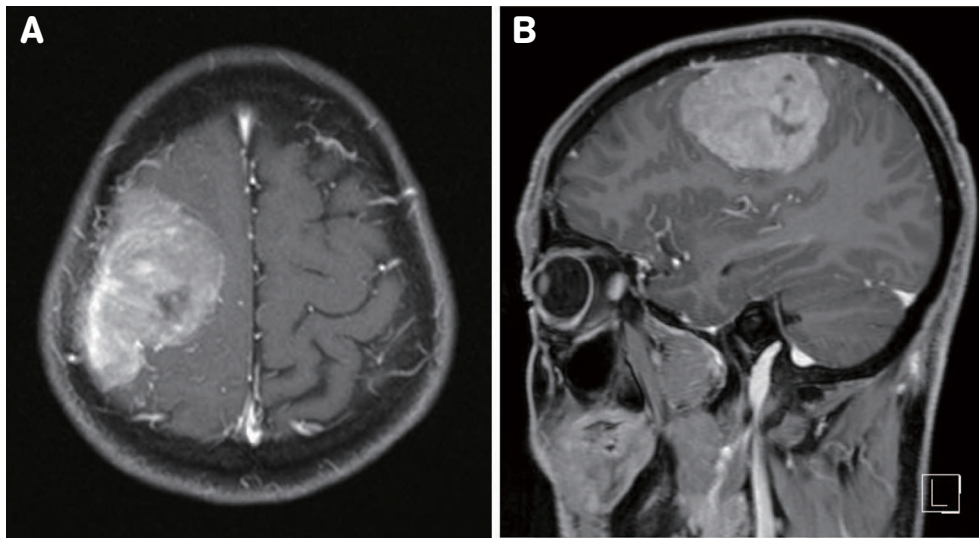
(A) Axial T1-weighted gadolinium-enhanced MRI reveals a $7.3 \times 5.1 \times 4.4$ cm lobulated circumscribed mass in right high convexity with moderate inhomogeneous enhancement and wide base attached to dura. (B) The presence of dural tail is demonstrated in sagittal T1-weighted gadolinium-enhanced MRI.
